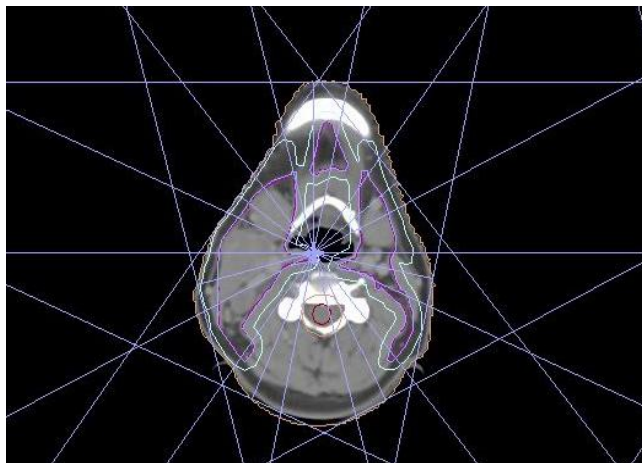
Example of CT image of head and neck cancer captured from Monaco TPS in AMDI, USM
